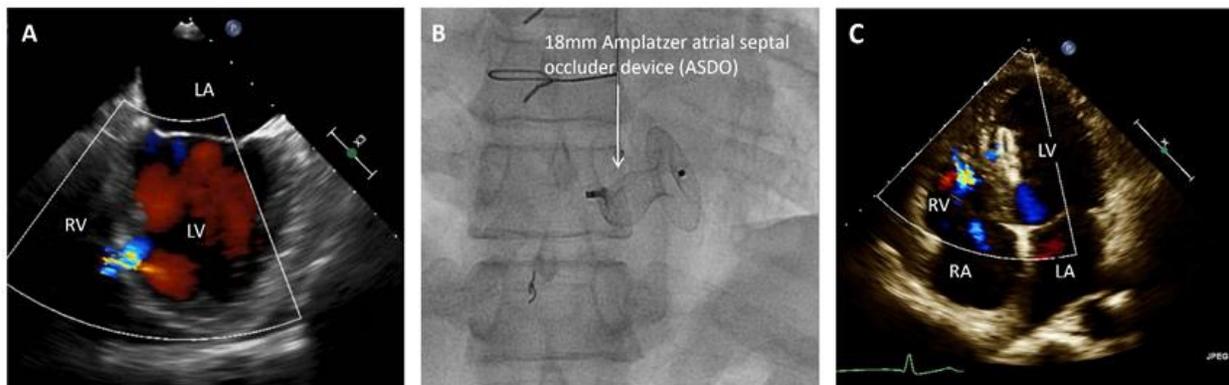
(A) Pre-operative transesophageal echocardiogram demonstrating left to right shunting through the VSD in the 4-chamber view. (B) Fluoroscopic still image of the successfully deployed 18mm ASDO. (C) An apical 4-chamber view from the one-month post-operative TTE which shows minimal residual shunting around the ASDO.
